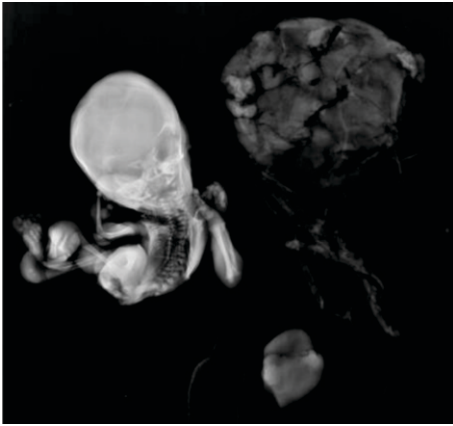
Post-Mortem Radiographic Finding Shows Absence of Right Femur with Short Tibia and Right Fibula, Complex Vertebral Malformation, Craniosynostosis, Overcrowding of Ribs.
